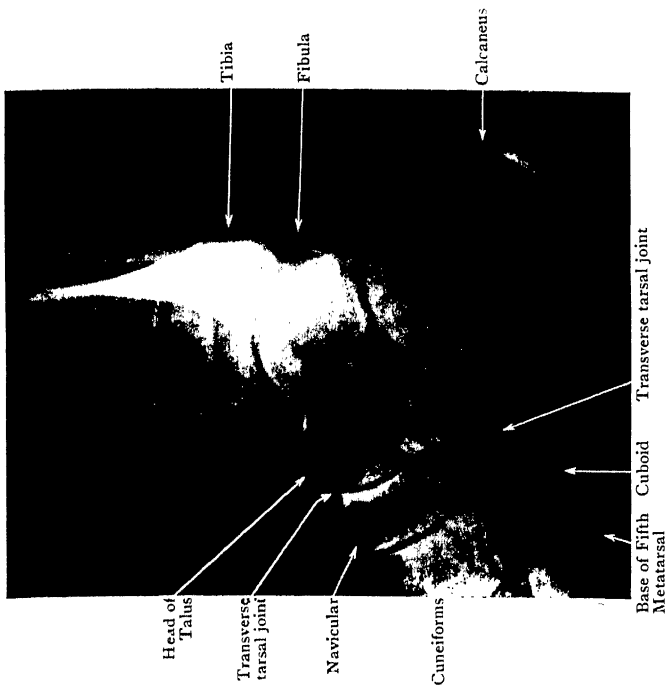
Lateral Radiograph of the same Ankle and Tarsus.
